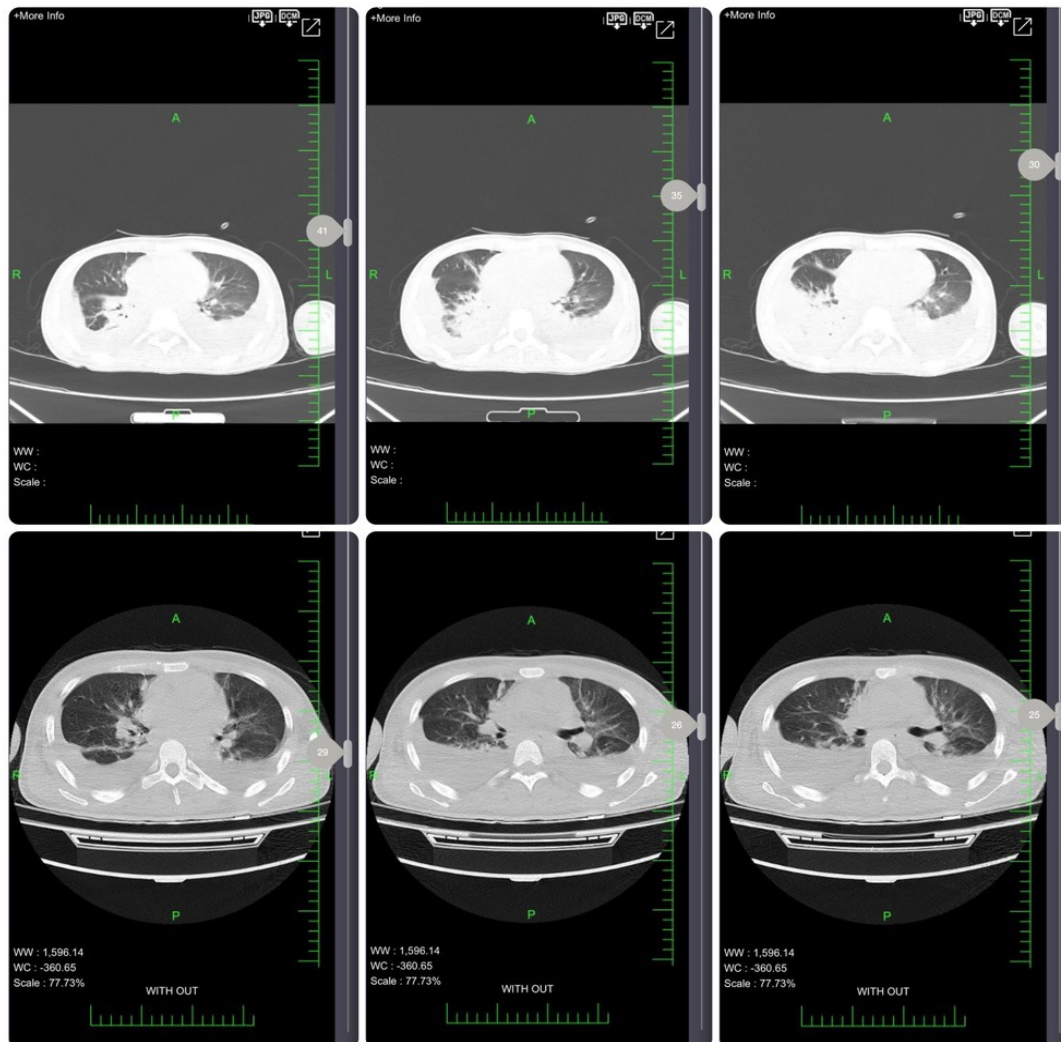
CT Scans of the Lungs , July 2025
